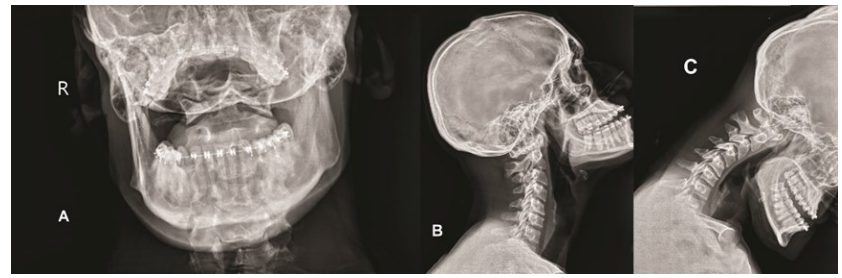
A Open-mouth X-ray before treatment shows atlas rotation to the right relative to the dens, consistent with a Type 1 anterior/posterior subluxation. B Lateral X-ray before treatment in extension showing no anterior/posterior subluxation of the C1. C Lateral X-ray before treatment in flexion showing no anterior/posterior subluxation of the C1. Same patient in figure 3.
